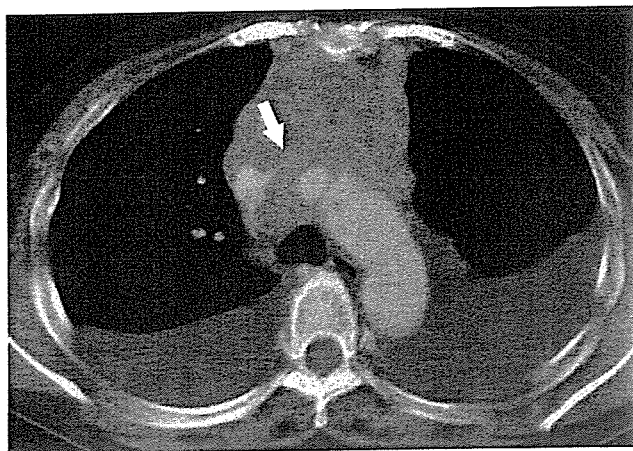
Thirty-two-year-old man with mediastinal diffuse large B-cell lymphoma (Med-DLBCL). CT image at the level of the aortic arch demonstrates a large, homogeneous enhancing anterior mediastinal mass without surface lobulation that compresses the left brachiocephalic vein (arrow). Also noted are bilateral pleural effusions.
